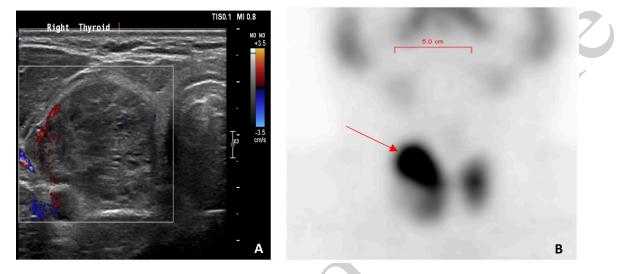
Thyroid Ultrasound (A) showing right thyroid nodule and Tc-99 thyroid scan (B) right hot nodule with increased total tracer uptake.
